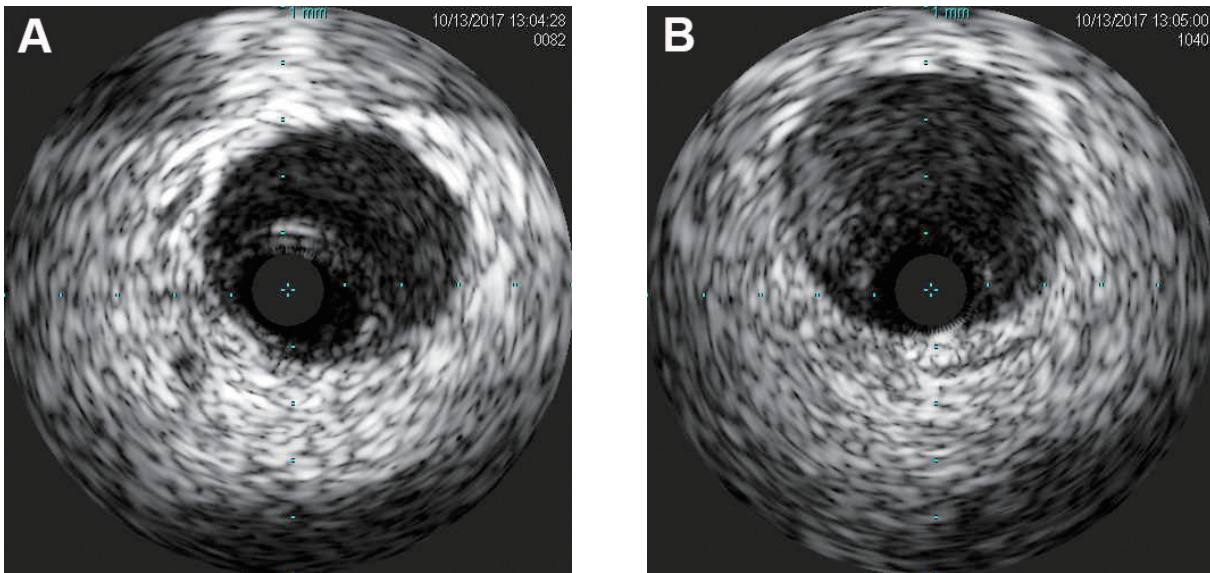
Intravascular ultrasound (IVUS) images.
